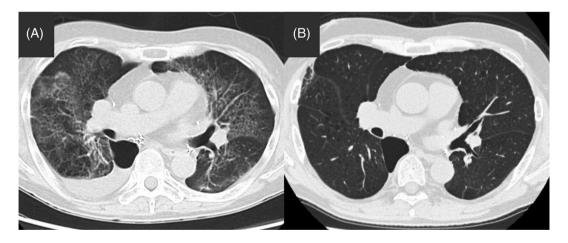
Computed tomography (CT) scan in case 2 displaying broadened bilateral centrilobular ground-glass opacities (GGO) (A: postoperative day [POD] 138) that disappeared after reduction of immunosuppressants (B).
